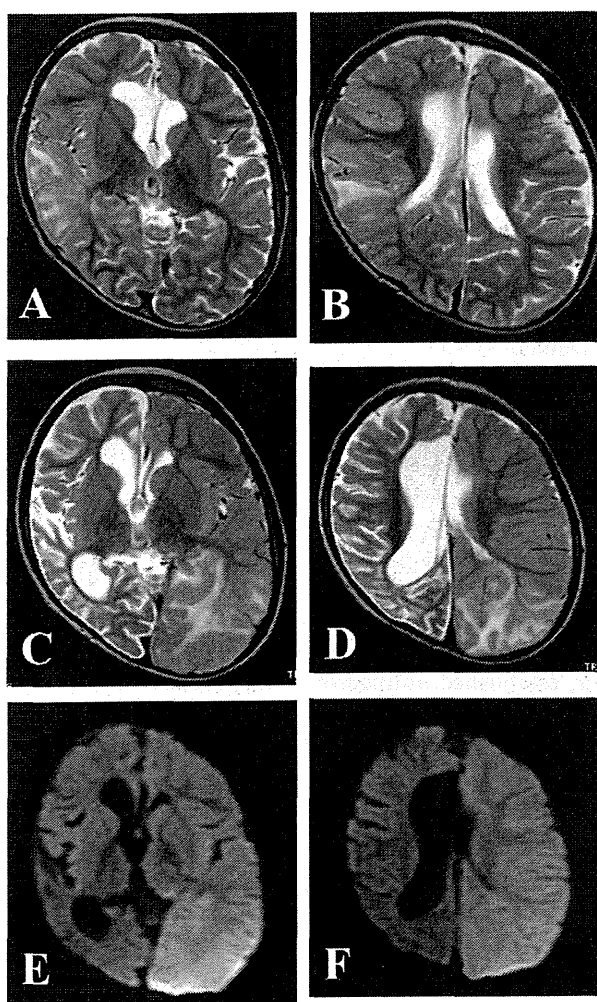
Magnetic resonance imaging (MRI) changes. At the time of the first epileptic episode (A, B), high-intensity signals of T2-weighted images on brain MRI were seen in the subcortical white matter in the right parietal and temporal cortices. At the time of the third episode, the white matter of the left temporal and occipital lobes showed high intensity in T2-weighted images (C, D) and edema in diffusion-weighted images (E, F), in addition to the right cerebral atrophy.
